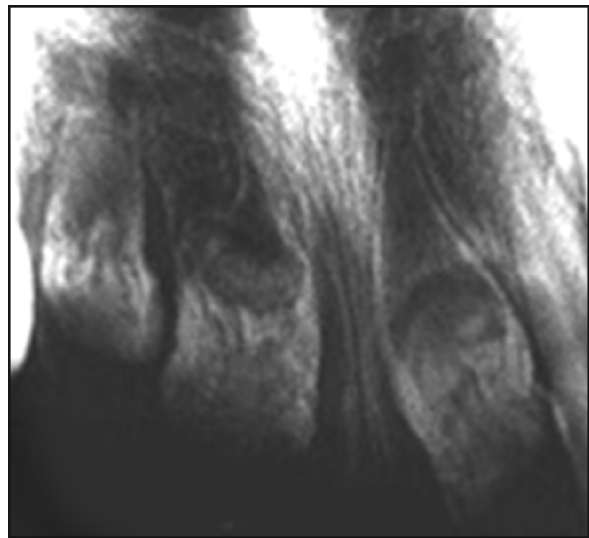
Radiographic picture of regional odontodysplasia showing ghost like teeth
